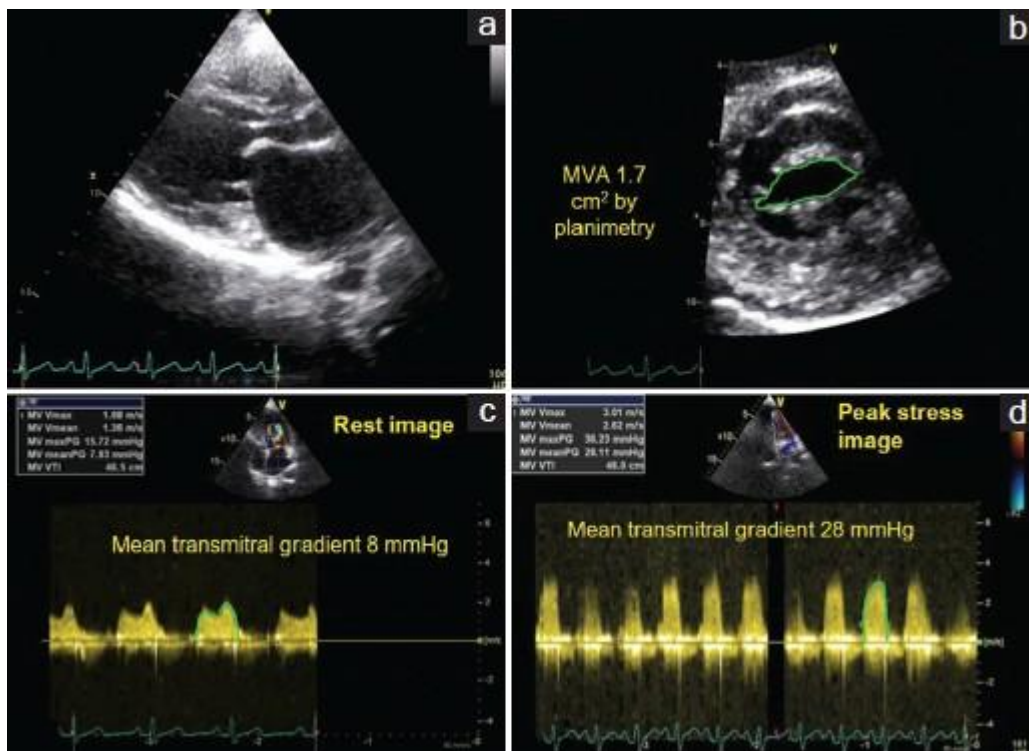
Anterior MV leaflets In long axis view (A), short axis view (b), continuous Doppler tracing of MV inflow to measure the pressure gradient across it (c, d).
